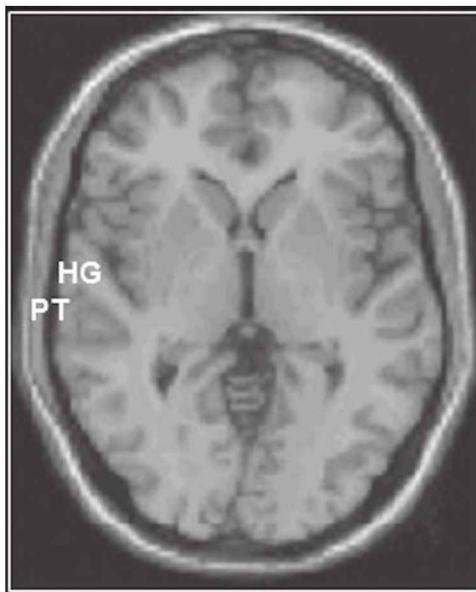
Anatomy of the Heschl’s gyrus (HG) and planum temporale (PT) in the temporal lobe plan seen in a horizontal MRI section in an adult individual, revealing the typical asymmetry of these brain structures.
